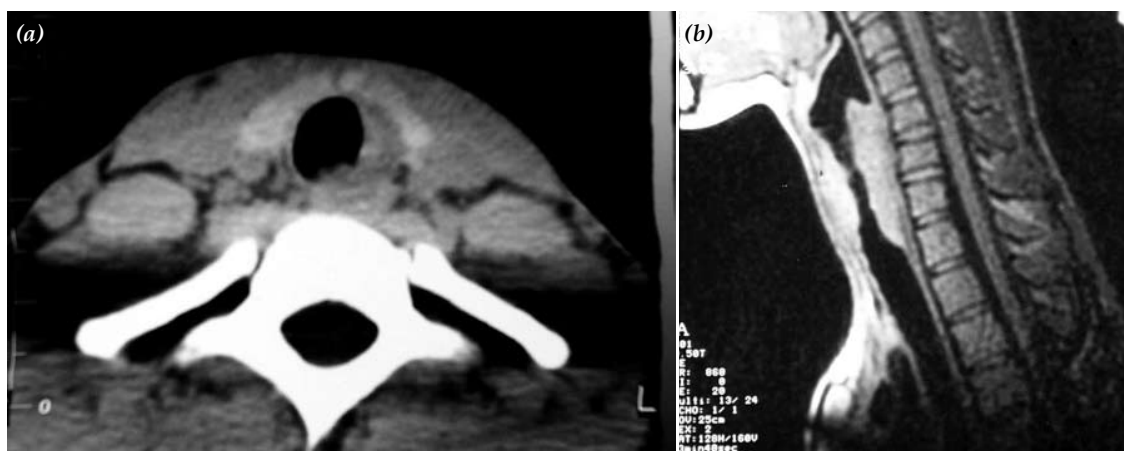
(a) Axial CT scan clearly indicates the subglottic mass. (b) Sagittal T₁-weighted magnetic resonance image demonstrating the mass with 3-cm subglottic extension.
